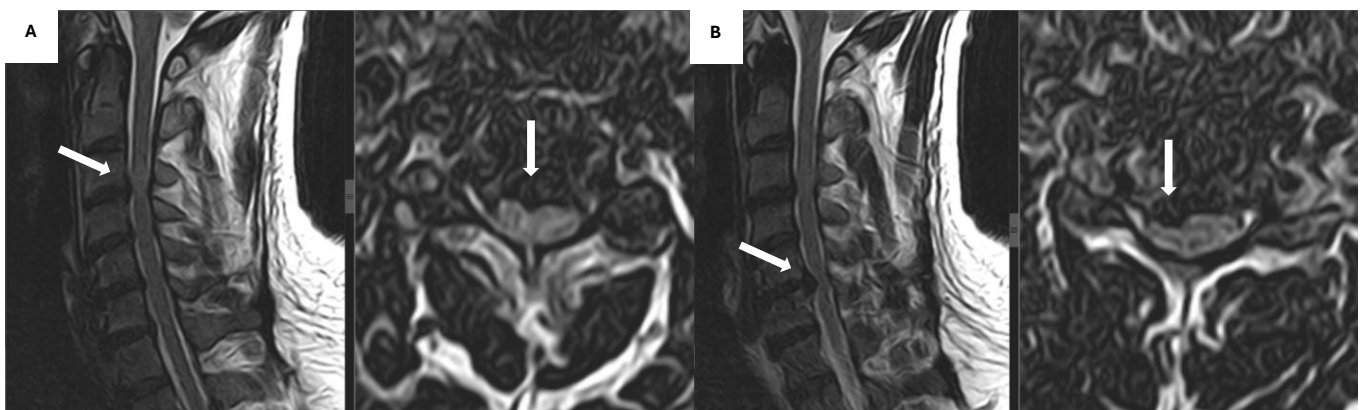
Pre-operative Non-contrast MRI imaging of the cervical spine. (A). T2-weighted image showing central cervical disc herniation without bony involvement at C3-C4 level, causing spinal cord signal changes (arrows). (B). T2-weighted image showing predominantly right sided cervical disc herniation without bony involvement at C5-C6 level, causing spinal cord signal changes (arrows).
